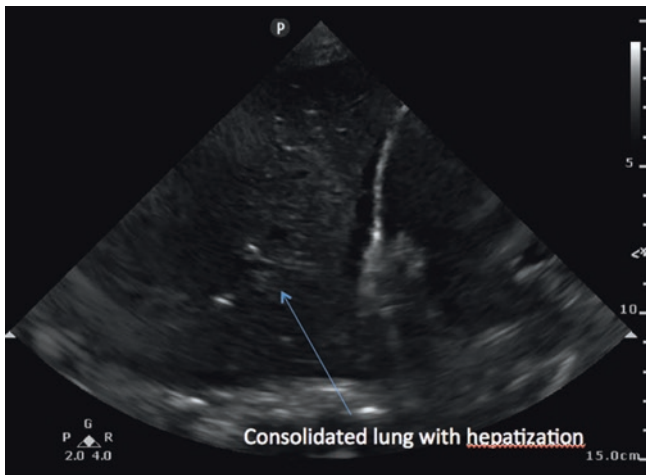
Lung ultrasound in patients with pneumonia. In patients with pneumonia, bedside ultrasound can demonstrate dense consolidation of the lung tissue characterized as “sonographic hepatization” of the lung. The consolidated lung tissue should be differentiated from the liver or spleen by demarcating the thorax from the abdomen using the diaphragm as the landmark. See also Video 37.5
